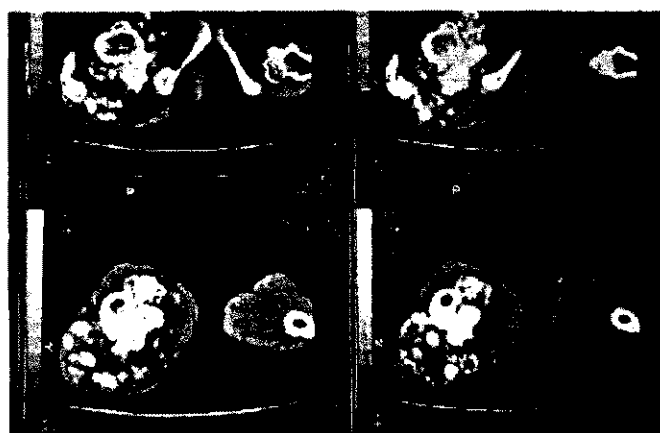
MRI showing extent of Tumour and Signs of Malignancy
